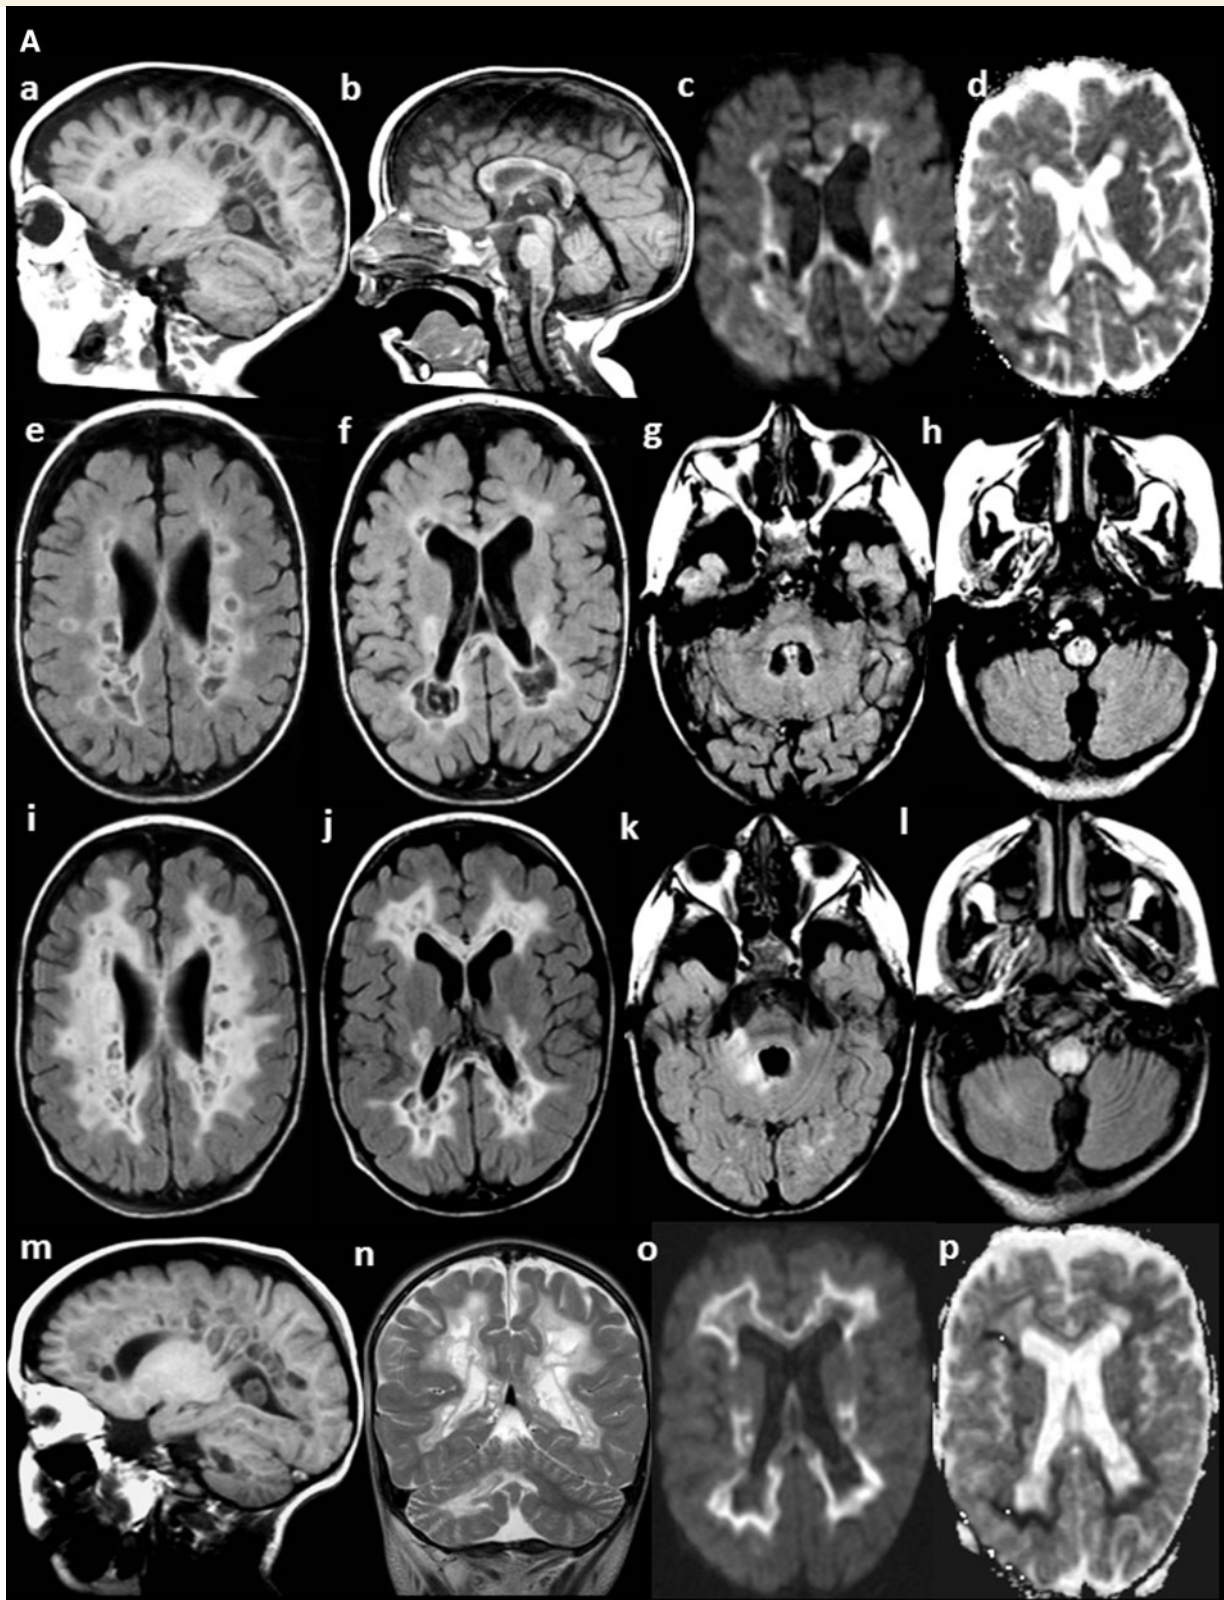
Brain MRI. (A) MRI of Patient 1 at the ages 19 months (a–h) and 3.5 years (i–p). At 19 months, the sagittal T₁-weighted (a and b) and axial FLAIR (e and f) images show signal abnormality and multiple small cysts in the periventricular and deep cerebral white matter, also involving the corpus callosum (b) and cervicomedullary junction (b and h). The diffusion-weighted images (c) suggest diffusion restriction in the abnormal, non-cystic white matter, confirmed by low signal on the ADC map (d). At 31 months, the white matter abnormalities have increased in extent and the cysts have in part become smaller (i, j and m). The middle cerebellar peduncle and cerebellar white matter are affected on the right (k and n). The cervicomedullary junction is still abnormal (l). Diffusion restriction is present in the solid part of the abnormal white matter (o and p).
